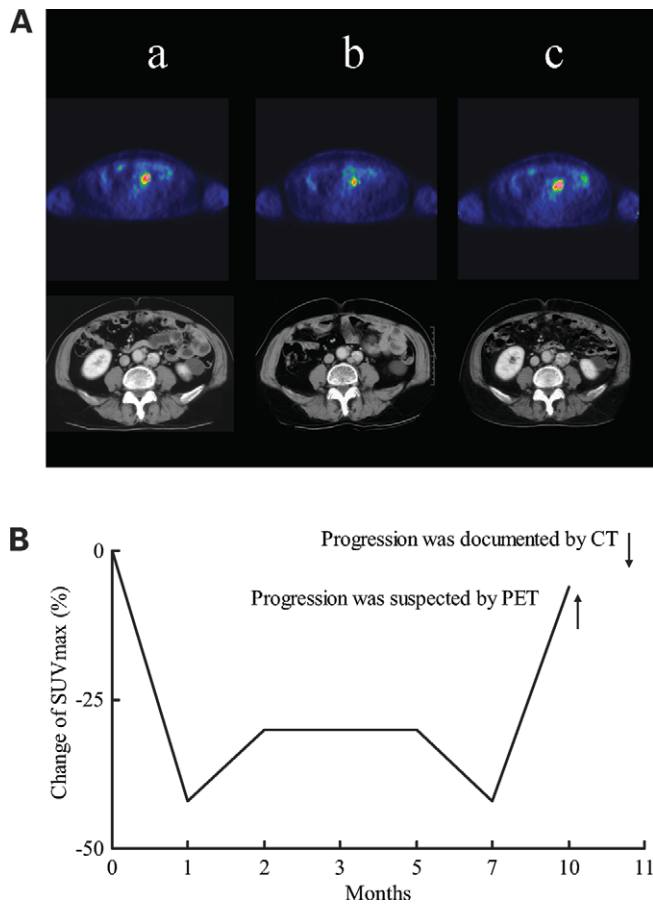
(A) Comparison of FDG-PET and CT with colorectal cancer with para-aortic lymph node metastases. Prolonged stable disease was documented by CT. a, before the treatment; b, the major reduction in FDG uptake was observed after 1 month of treatment, but no volume change was observed by CT; c, progression in FDG uptake was observed after 10 months of treatment, but no major volume change was observed by CT. (B) The time course of the SUVmax and tumor response in a patient with colorectal cancer with prolonged stable disease. The SUVmax was decreased by 42% from baseline after 1 month treatment, and maintained thereafter for 9 months. The SUVmax also began to increase 1 month earlier than the documentation of disease progression by CT.
